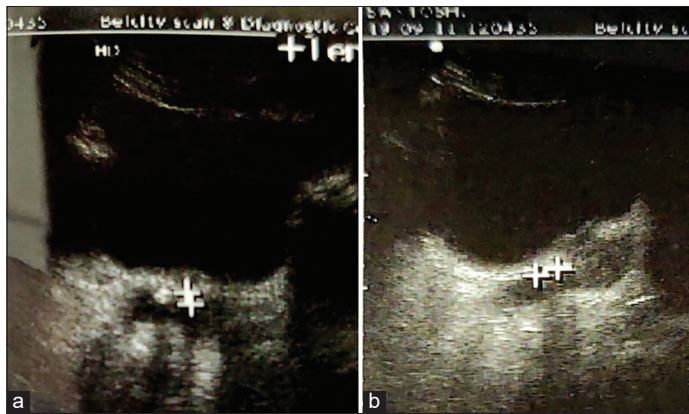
Ultrasonography showing (a) dilated left seminal vesicle and hyperechoic calculus with posterior shadow measuring 5 mm; (b) dilated right seminal vesicle and hyperechoic calculus with posterior shadow measuring 8.5 mm
